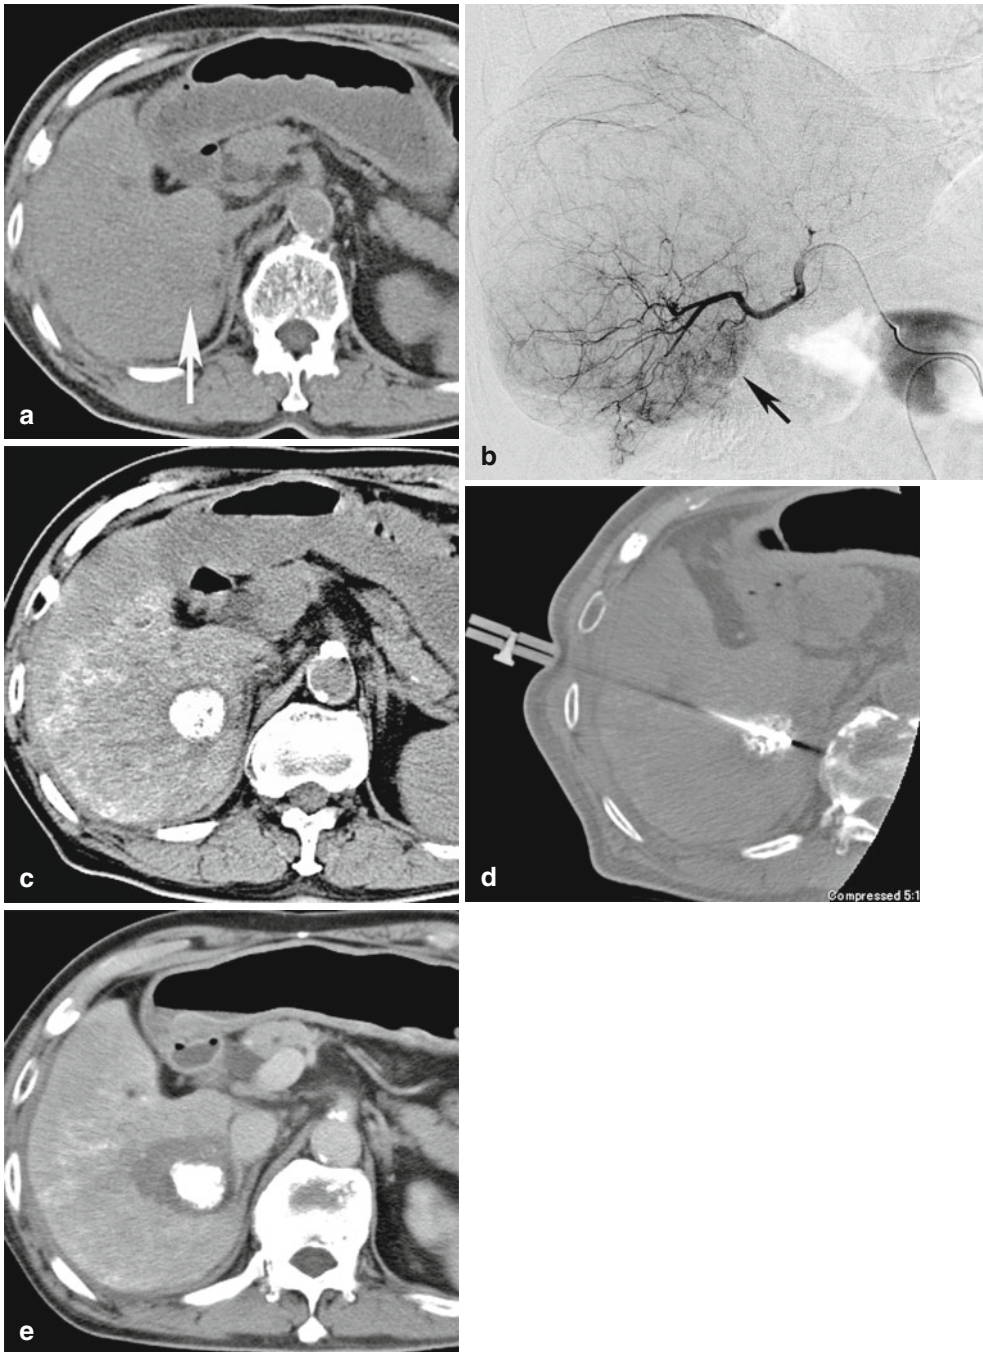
RF ablation after segmental Lipiodol-TACE for an HCC which was invisible on US and hardly detectable on unenhanced CT. (a) Unenhanced CT before treatment shows a slightly hypodense tumor in segment VI (arrow). (b) Selective arteriography shows a hypervascular area with a badly defined margin (arrow). After
